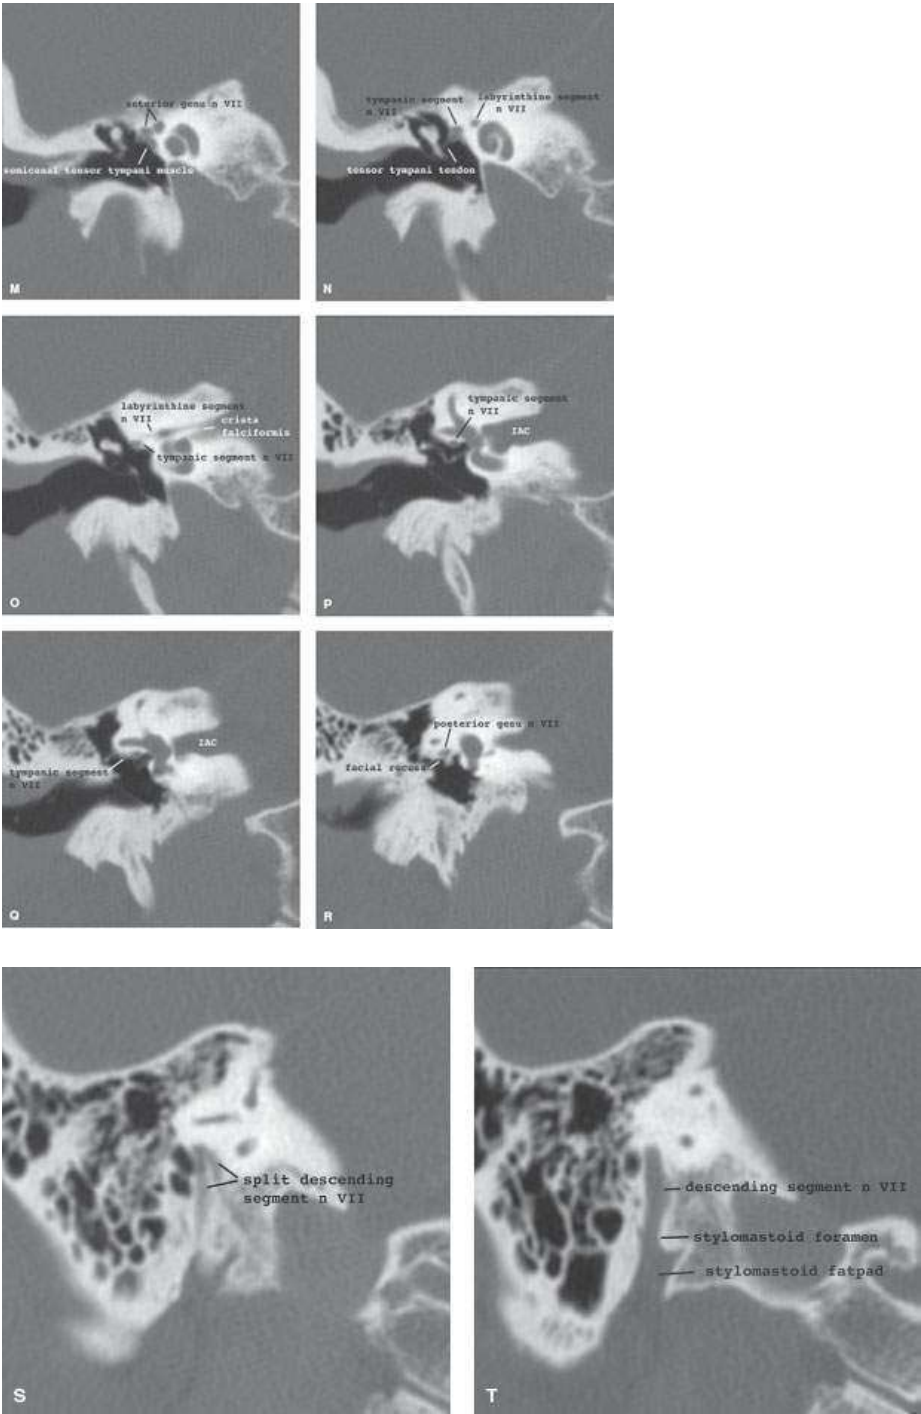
Normal anatomy of course of the facial nerve through the temporal bone on axial (A–J) and coronal (K–T) computed tomography images.
